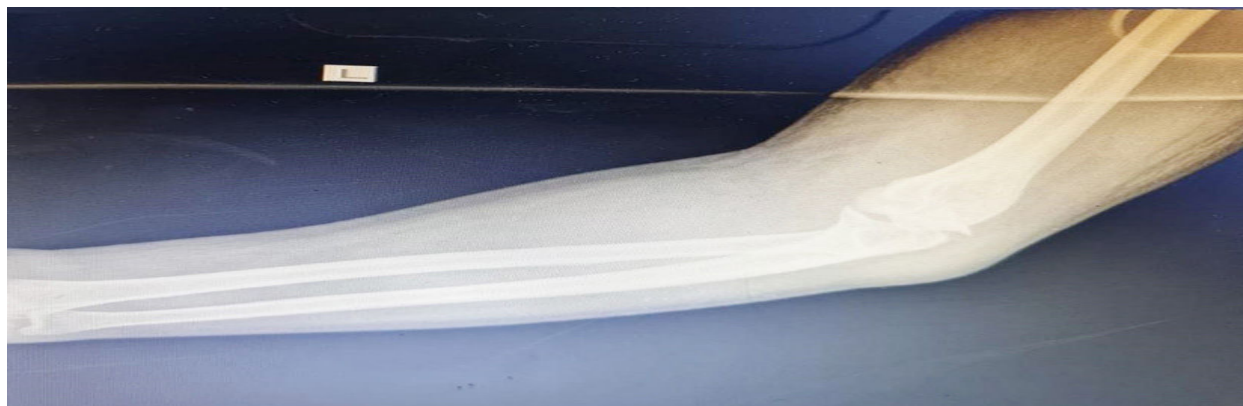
Left forearm and arm X-ray AP view showing no long bone fractures
